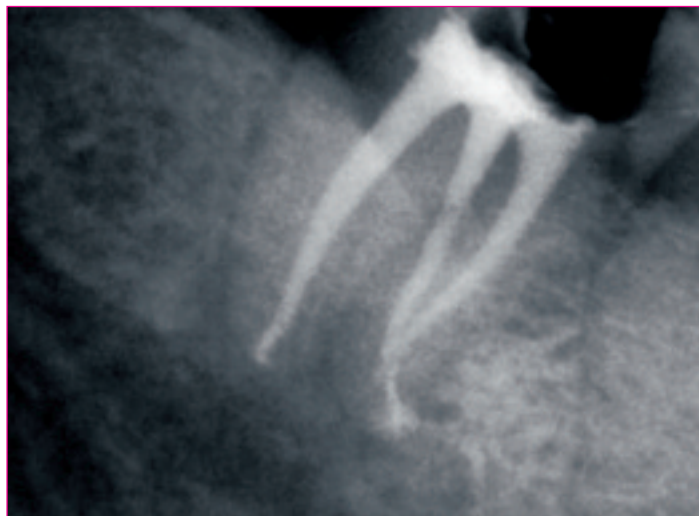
With the aid of a second Xray (with different angle) we can see the real anatomy and how the two mesial roots are crossing in the last two mm.
